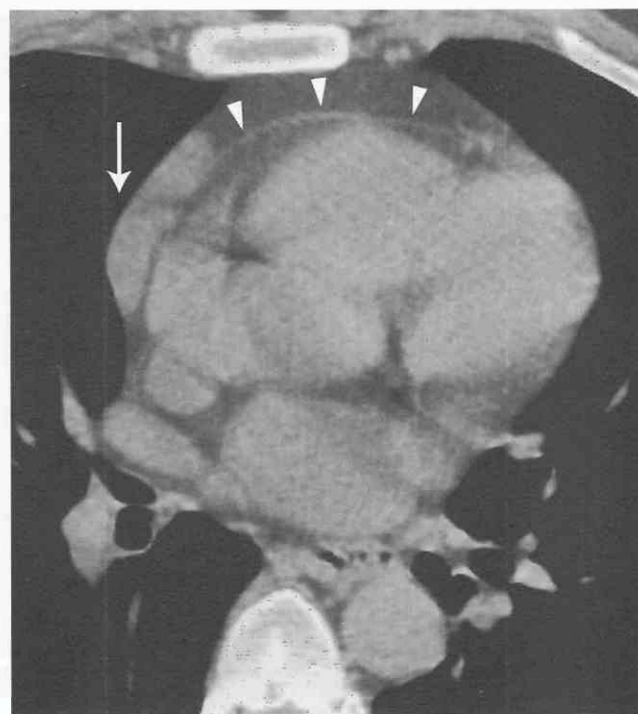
Pericardial cyst. Axial CT scan without contrast medium shows an elongated mass (arrow) arising from the pericardium (arrowheads). The mass, whose density was similar to that of water, was resected and found to be a pericardial cyst.
